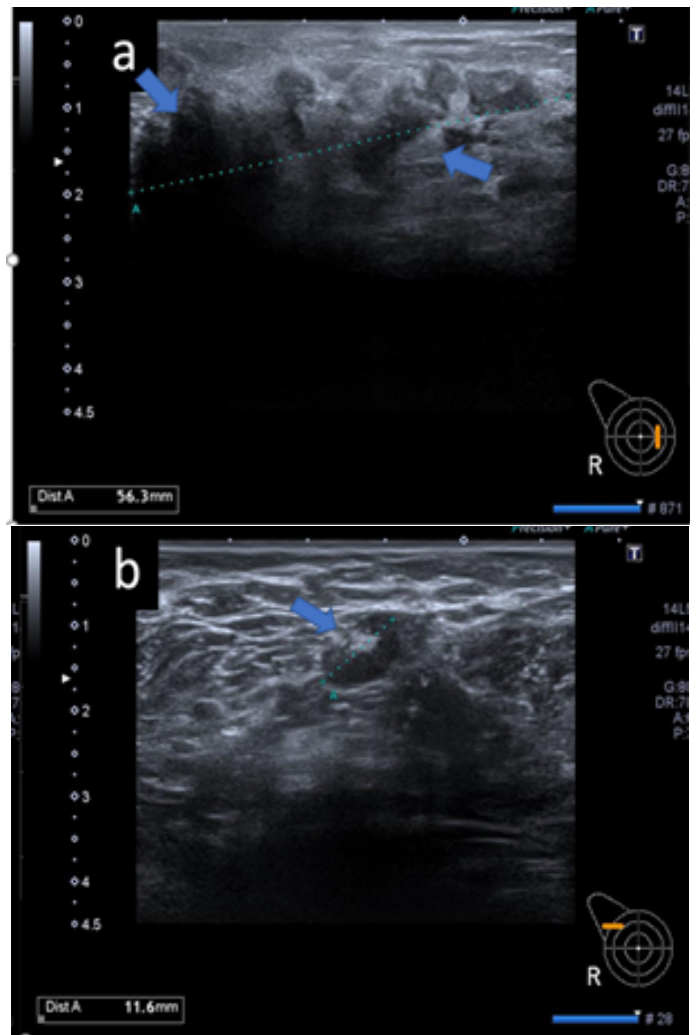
a) Ultrasound (US) image of the inner right breast shows a large non-mass heterogeneous area with distorted contour and atypical dense content (arrows) b) Sonogram shows cortical thickening of the lymph node (arrow).
